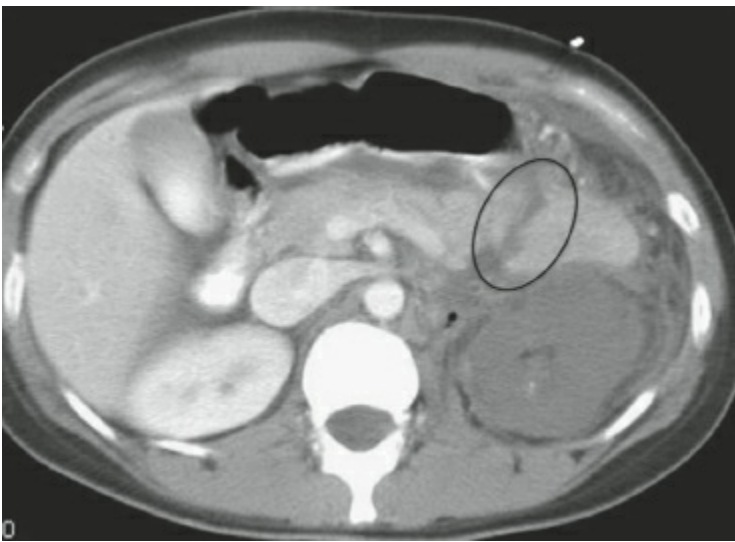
CT image of pancreatic transection after blunt trauma. Oval demonstrates the pancreatic transection.
